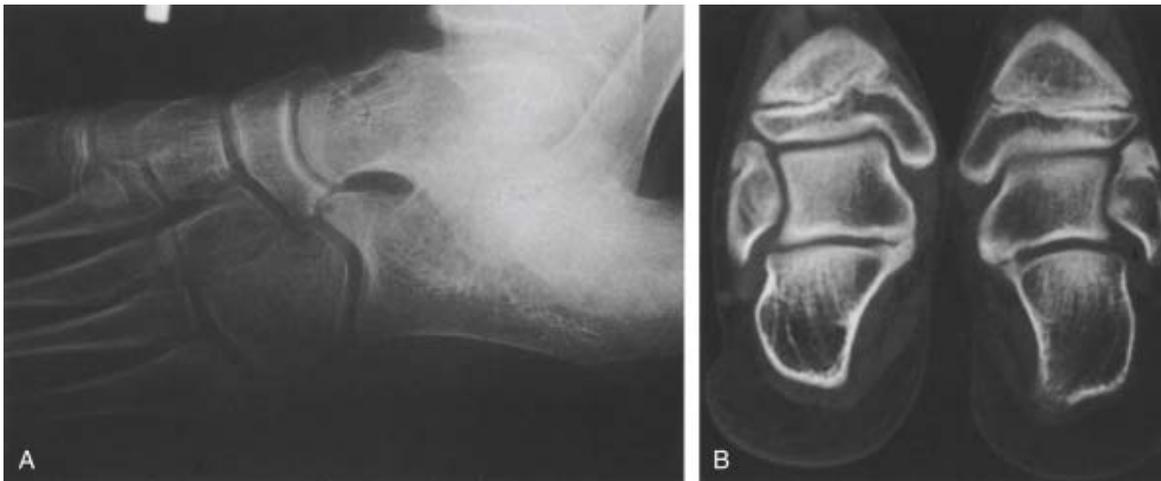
Figure 25C2-2 Plain radiography (A) and computed tomographic scan (B) showing calcaneonavicular and talocalcaneal coalitions, which occurred bilaterally in this patient. The patient presented with a painful, rigid foot and was having difficulty playing tennis.
